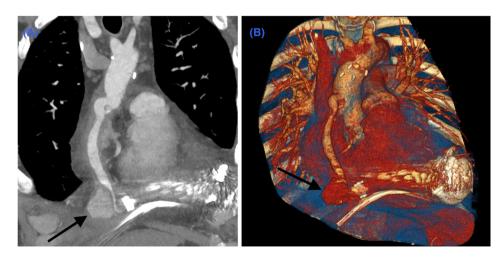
(A) Coronal computed tomography angiography image demonstrating the pseudoaneurysm causing significant compression on the outflow graft of the pump (black arrow). (B) Three-dimensional computed tomography angiography reconstruction demonstrating the pseudoaneurysm (black arrow).
